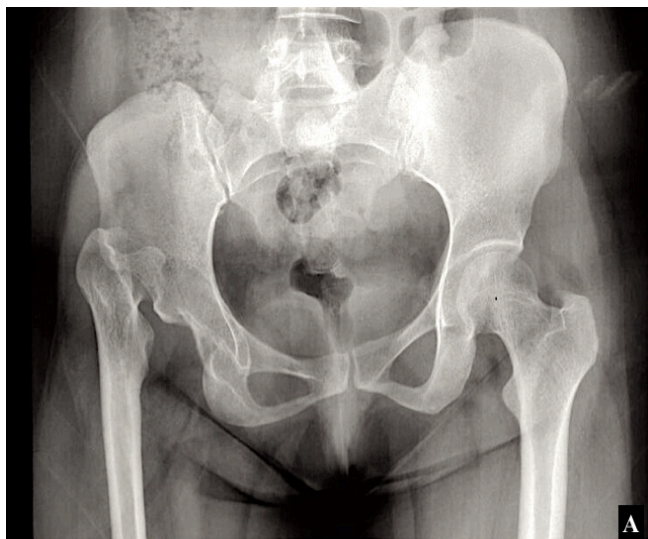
X-ray of pelvis with both hips in Antero-Posterior view showing dysplastic right hip.
